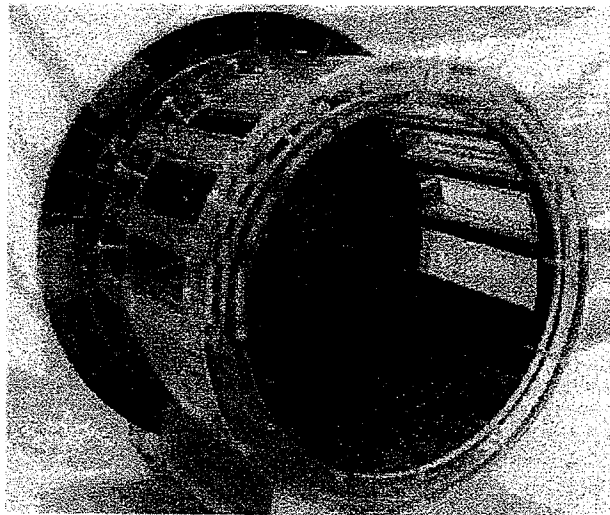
Quadrature birdcage coil with endcap used for whole-volume head imaging (reprinted with permission from J. R. Hadley et al¹¹ © *Journal of Magnetic Resonance Imaging* 2000)
